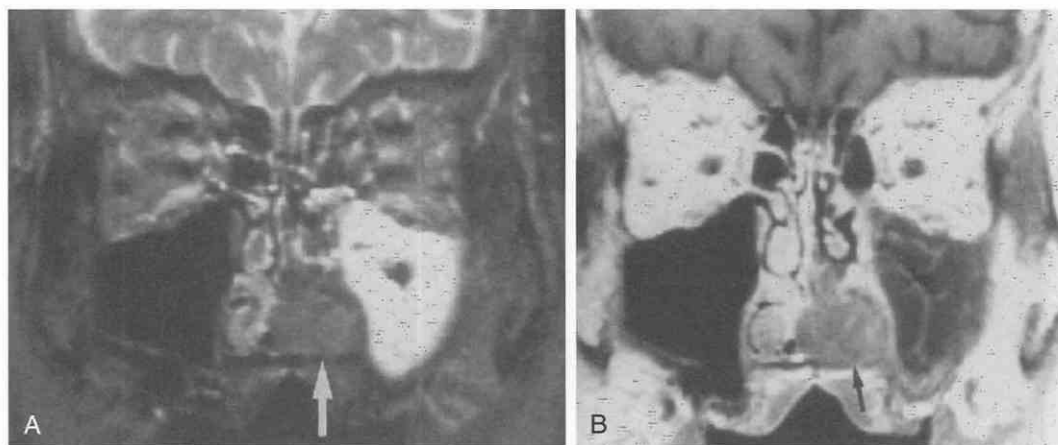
Squamous cell carcinoma. A, On this coronal T2-weighted image (TR3000, TE60), structures containing water, such as cerebrospinal fluid and inflammatory polyps, in the left maxillary sinus are of increased signal intensity. More cellular masses such as skeletal muscle and the mass within the inferior meatus on the left (arrow) are of more intermediate signal intensity. Cellular masses within the nasal cavity and sinonasal tract should be suspected of being neoplasms. B, The accompanying post-contrast-enhanced T1-weighted image (TR500, TE32) shows the expected surface linear enhancement on the inflammatory polyps in the left maxillary sinus (arrow). The turbinates and normal nasal mucosa enhance brightly inhomogeneously. The suspected nasal mass enhances somewhat less intensely than the normal turbinates. This is a biopsy-proven squamous cell carcinoma.
